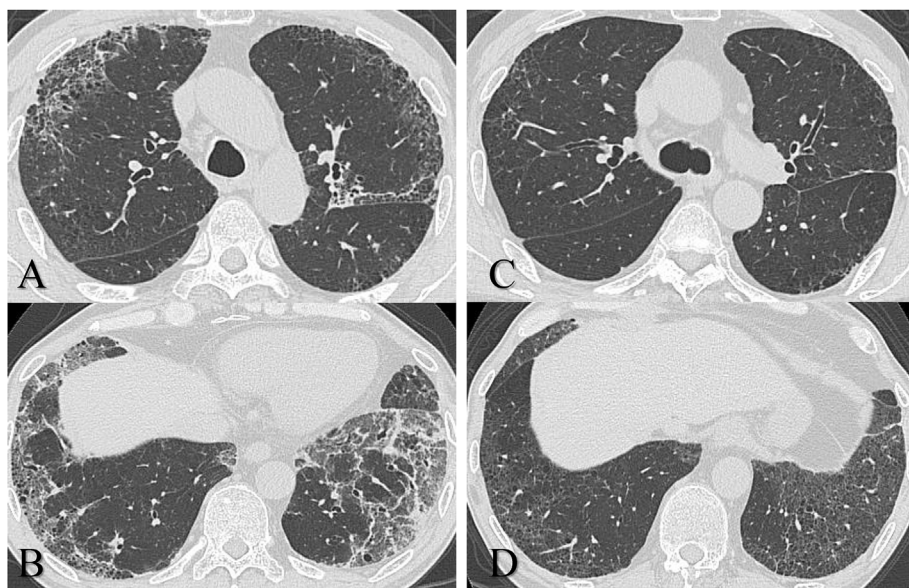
High-resolution computed tomography findings. (A, B) Chest computed tomography showed emphysema in the upper lung and wide-ranging ground-glass attenuation and reticulation with lower-lobe predominance. Ground-glass attenuation was distributed mainly in the peripheral areas and partially along the bronchovascular bundles. (C, D) At 3 months following the diagnosis of DIP, immunosuppressive treatment with prednisolone led to an improvement in the radiological findings.
